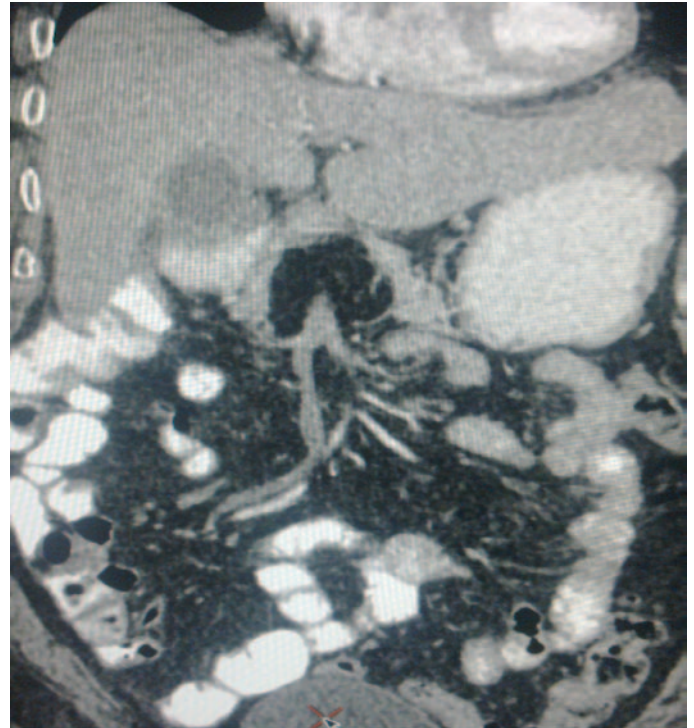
Contrast-enhance CT Computer Tomography.
